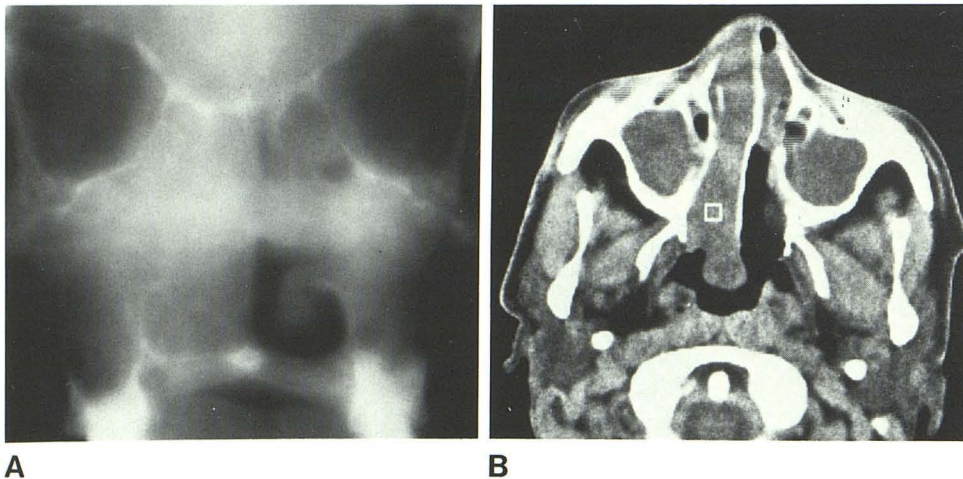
Allergic polyps suggesting neoplasm; soft-tissue mass protruding out of nares. A, Conventional tomogram. Opacification of nasal and maxillary antral cavities; evidence of bony erosion was equivocal. B, Axial CT sections. Soft tissue within nose and maxillary antra extends into ethmoids. Thickening of maxillary antrum walls suggested chronic process; no bony erosion was noted. Density analysis revealed CT numbers within maxillary antrum to be 25 units less than those of nasal soft tissue, suggesting obstruction of sinuses, rather than tumor invasion. Biopsy disclosed allergic polyp.
